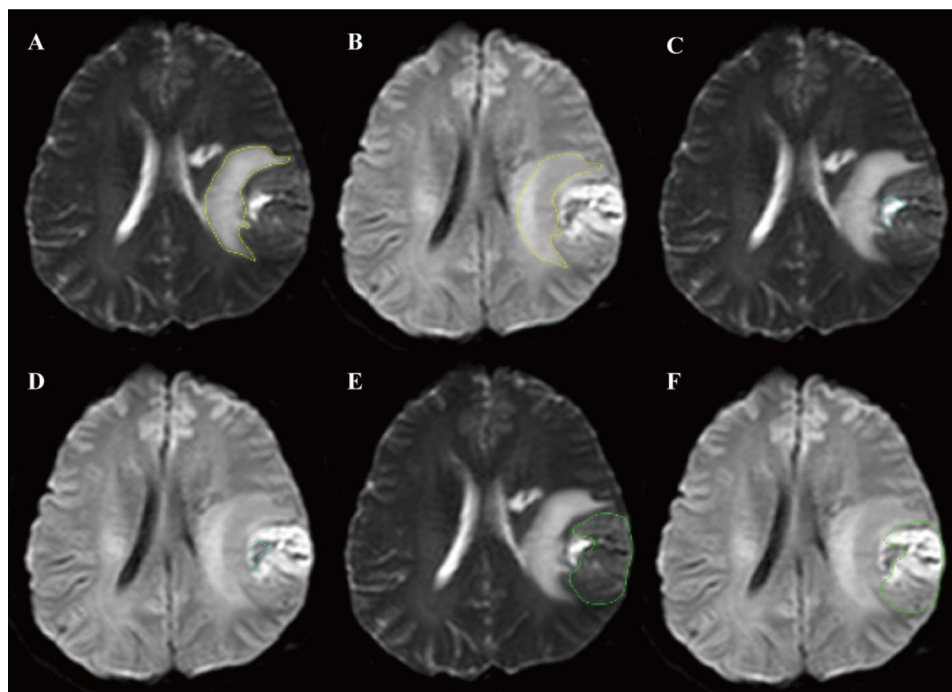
Tumor segmentation in DWI MRI. (A) non-enhancing peritumoral area in DWI with the b-value of 0 s/mm^2 . (B) non-enhancing peritumoral area in DWI with the b-value of 1000 s/mm^2 . (C) Necrotic area in DWI with the b-value of 0 s/mm^2 . (D) Necrotic area in DWI with the b-value of 1000 s/mm^2 . (E) Parenchymal area in DWI with the b-value of 0 s/mm^2 . (F) Parenchymal area in DWI with the b-value of 1000 s/mm^2
